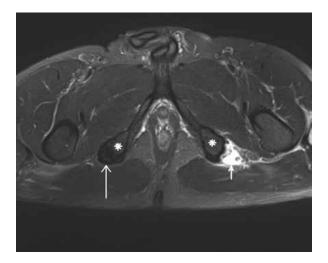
Axial MRI image of the avulsion of left hamstrings. Asterisk marks the ischial tuberosities. Hematoma (small arrow) can be seen on the left side whereas on the right side the tendons (long arrow) attach normally to the tuberosity.
